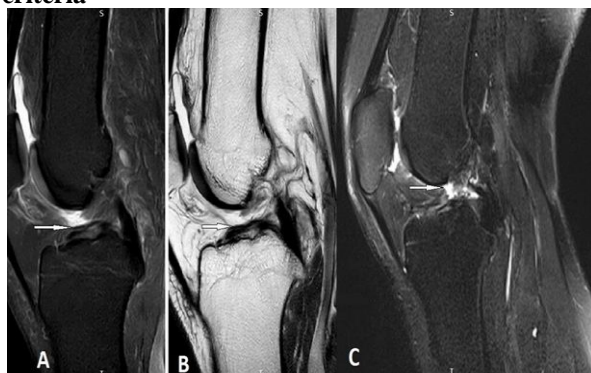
shows a complete ACL tear (white arrows) in both (A) sagittal proton-density fat-suppressed MRI and (B) sagittal T2-weighted fat-suppressed MRI. (C) A mid-substance fibre rupture is visible on the T2-weighted fat-suppressed sagittal MRI (white arrow).
